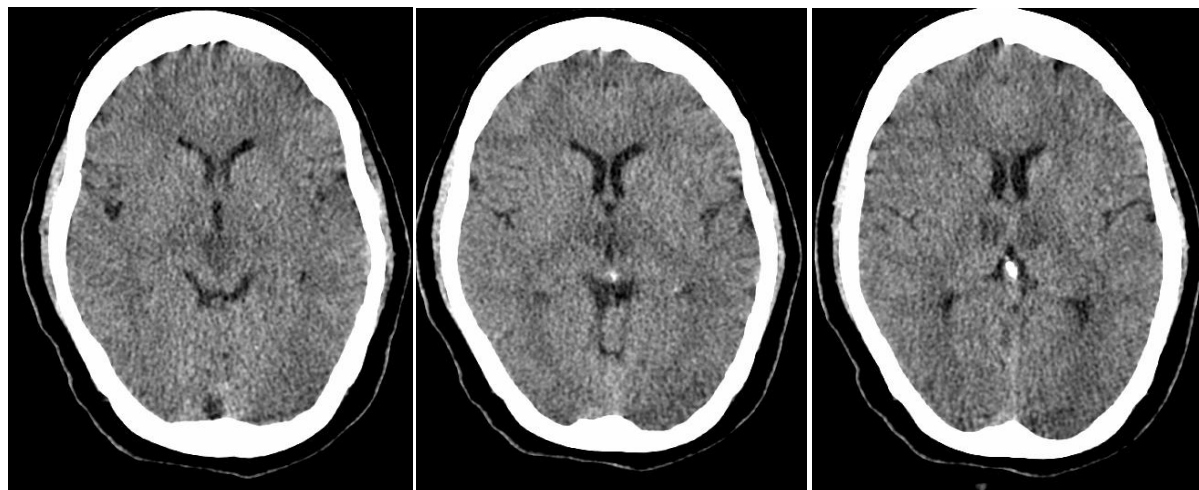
Non contrast CT imaging 8 hours after the onset of symptoms showed signs of infarct in paramedian regions of both thalamii and in rostral midbrain .
